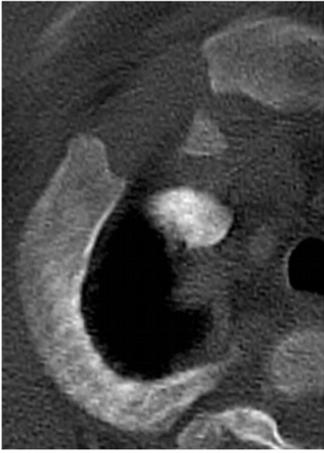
The CT image of the first cartilage stage.
